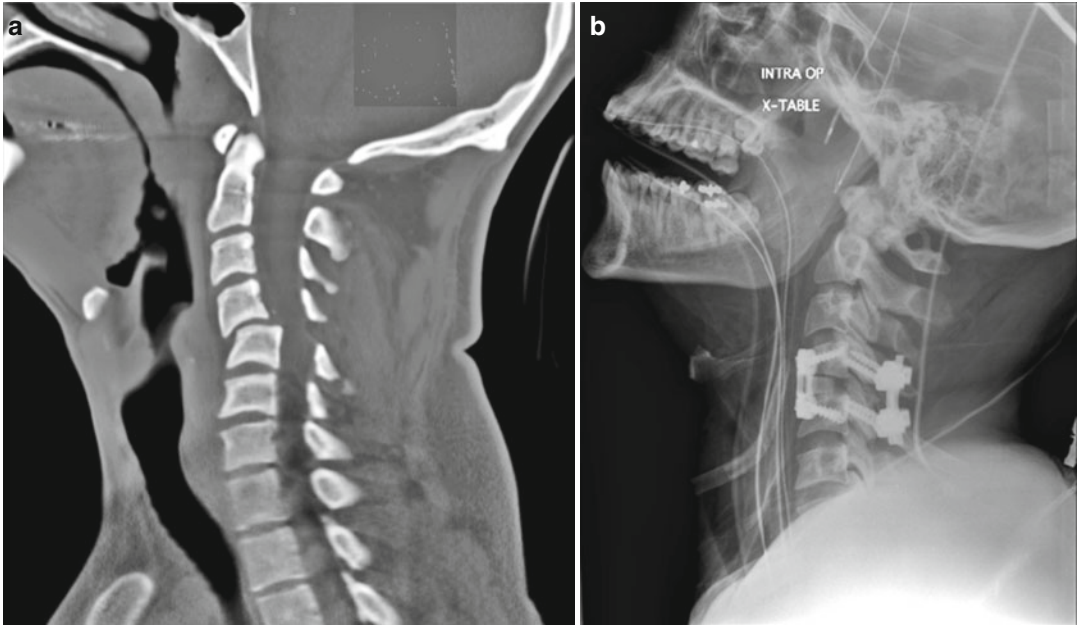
(a) C4–5 bilateral facet dislocation. (b) Postoperative radiograph demonstrating anterior fixation with a plate and allograft fibula and posterior fixation with lateral mass screws and rods
